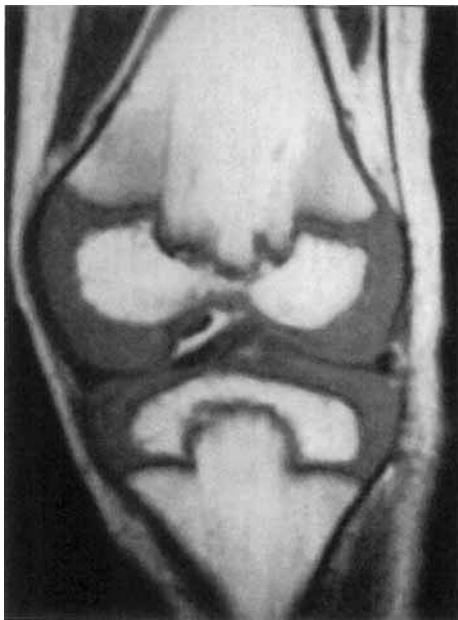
Patient 2 at 4½ years. MRI (T1-weighted) in coronal plane of left knee showing central extension of metaphysis into the epiphysis of distal femur and proximal tibia. Note irregular but intact physis and normal marrow signal intensity.
